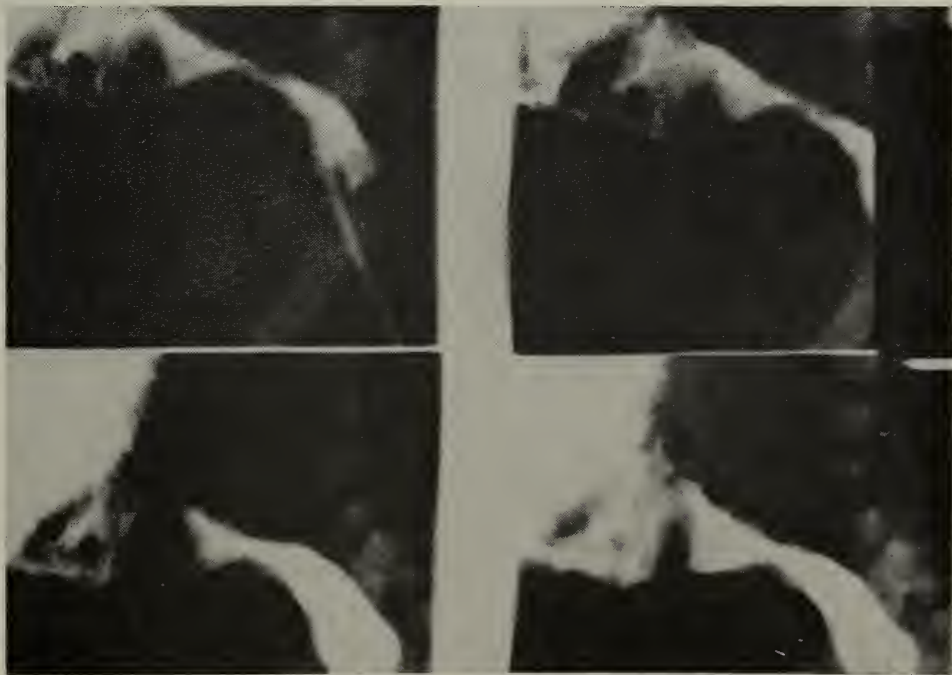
Case 2—X-rays of barium enema showing a narrowed recto-sigmoid segment.
